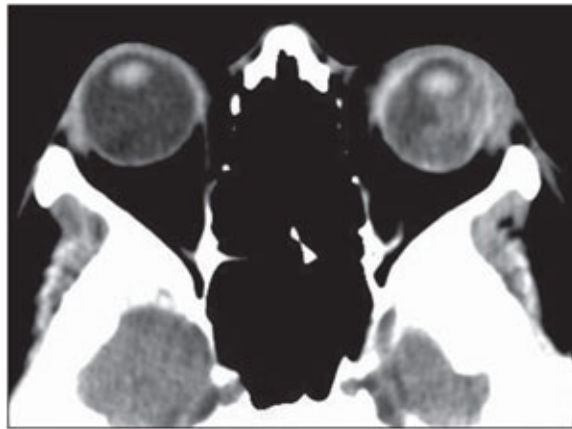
CT scan demonstrating globe rupture on the left.
